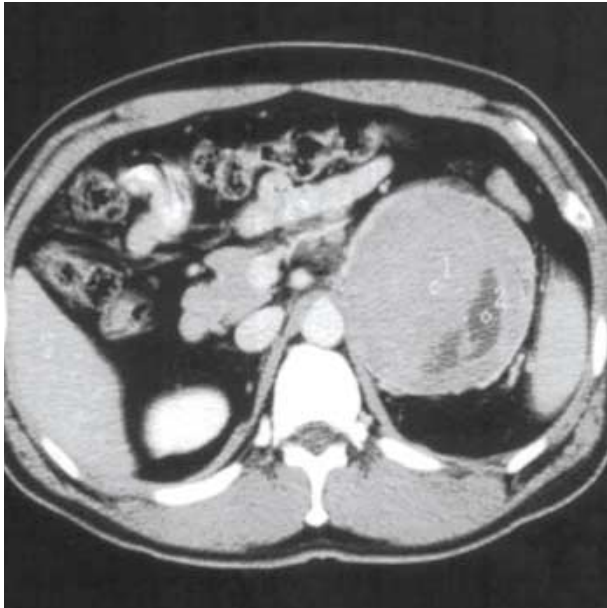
Abdominal CT scan shows a well defined, isodense and homogenous left adrenal gland mass with geographic central low density lesion, measuring 11 cm in diameter.
